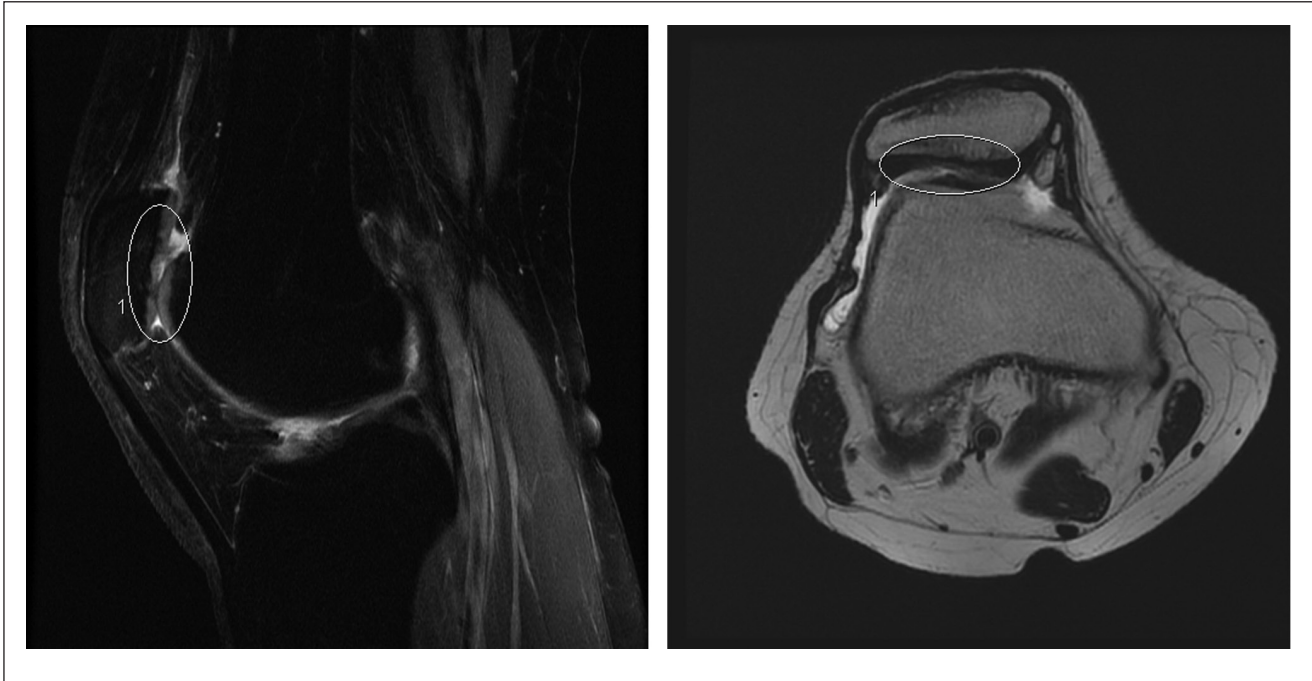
Preoperative MRI scan of patellar defect, measured by radiology as 14 mm × 9 mm (1.3 cm²). Fast spin echo, fat-suppressed proton density sagittal image (left), and fast spin echo axial image (right). The defect areas are outlined.
